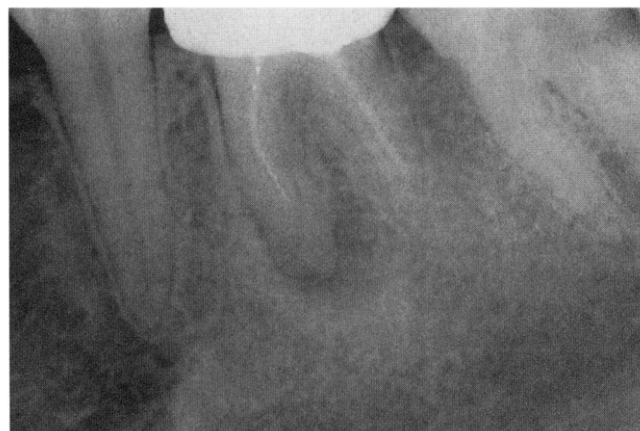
Preoperative radiograph of a mandibular right first molar demonstrates a mesial root with an apical pathology, a broken instrument at its middle third, and an underfilled distal canal.
